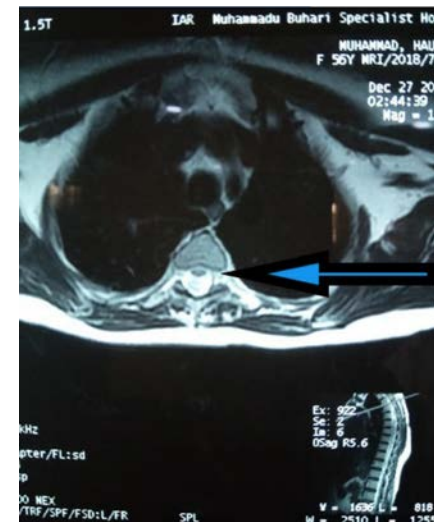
The axial sequence thoracic spine T2-weighted MRI (using 1.5 tesla scanner) revealing associated widening of the thecal sac suggestive of anterior spinal cord infarction with no signal changes seen within the substance.
